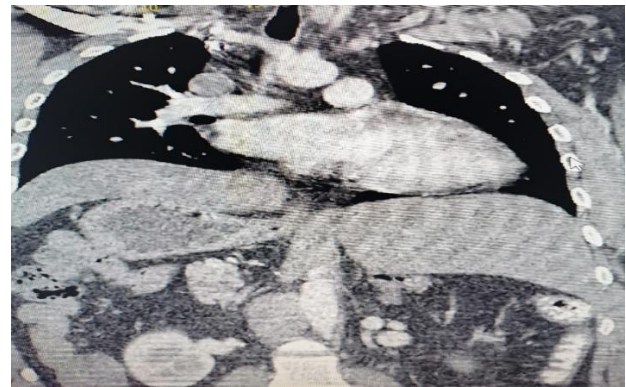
CT scan showing apex of the heart on left, larger lobe of the liver on the left and stomach on right side.
